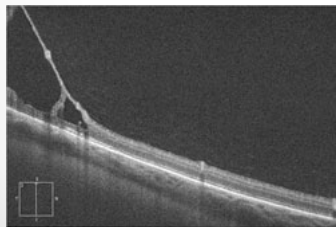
High-resolution ultrasound (USO) B scan of eyes with (A) RS and (B) RD. Panel A shows that eyes with RS demonstrate a thin single hyper-reflective line representing the RNFL interface (blue arrowhead) in the split inner retina. The schisis cavity is marked by a blue asterisk. The OPL and RPE interfaces are shown with a white and yellow arrowhead, respectively. Panel B shows that eyes with RD demonstrate the presence of two hyper-reflective lines representing the RNFL and OPL interfaces (blue and white arrowheads) in the detached portion of the retina. The red asterisk marks the subretinal space overlying the RPE interface, which is attached (yellow arrowhead).
